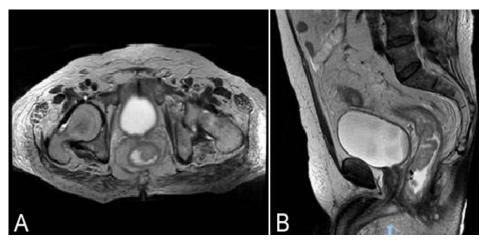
MRI with intravenous contrast and endorectal gel in T2 sequence. Axial (A) and sagittal (B) images showing an elevated and polylobulated lesion on the anterior surface of the middle and lower rectum. T2N0M0.
